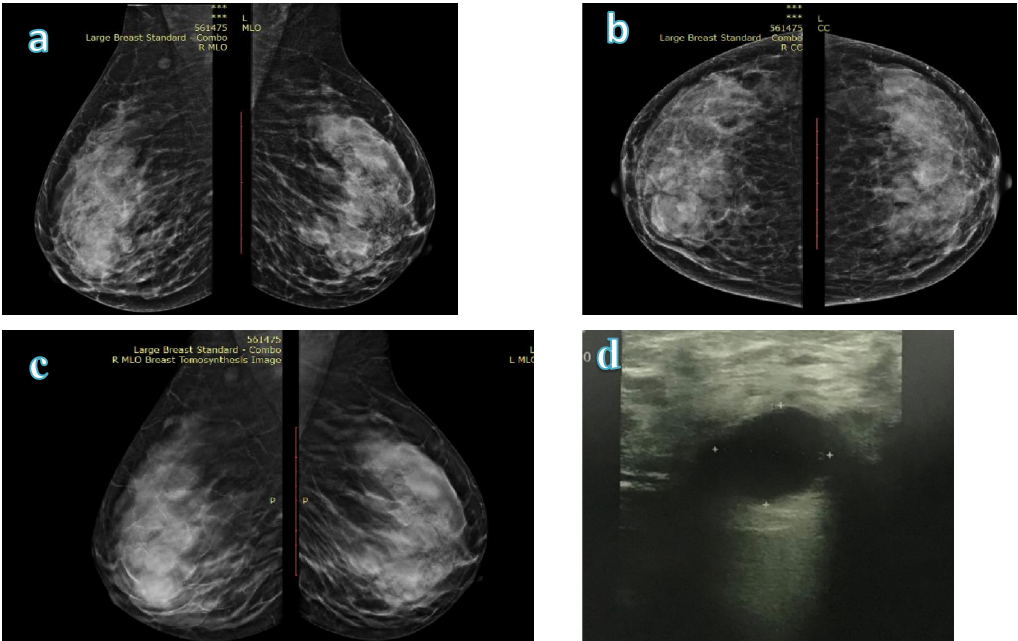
(a) Craniocaudal, (b) mediolateral oblique DM images of both breasts revealed bilateral heterogenous dense parenchyma (ACR C) and bilateral diffuse nodular increased density with obscured margin (BIRADS III). (c) Thin cuts tomosynthesis revealed bilateral multiple well circumscribed oval and rounded lesions surrounded by a radiolucent halo confirming the benign nature (BIRADS II). (d) Ultrasound showed a well-defined anechoic simple cyst.
